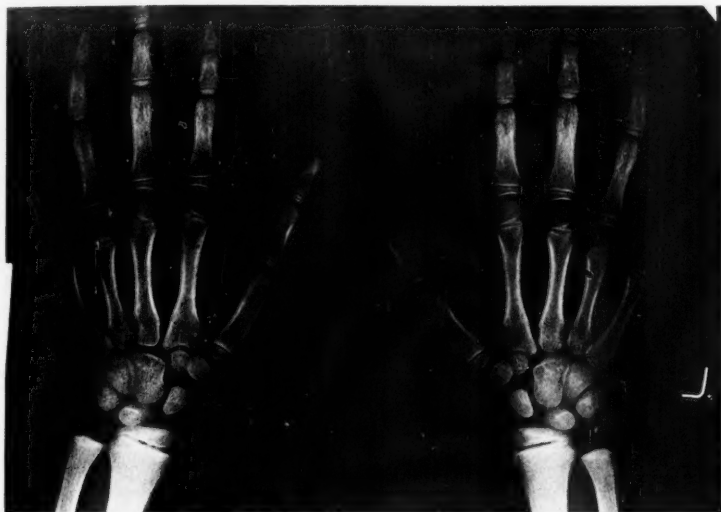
Roentgenogram of female, aged seven, male offspring. (Table I-g.)
